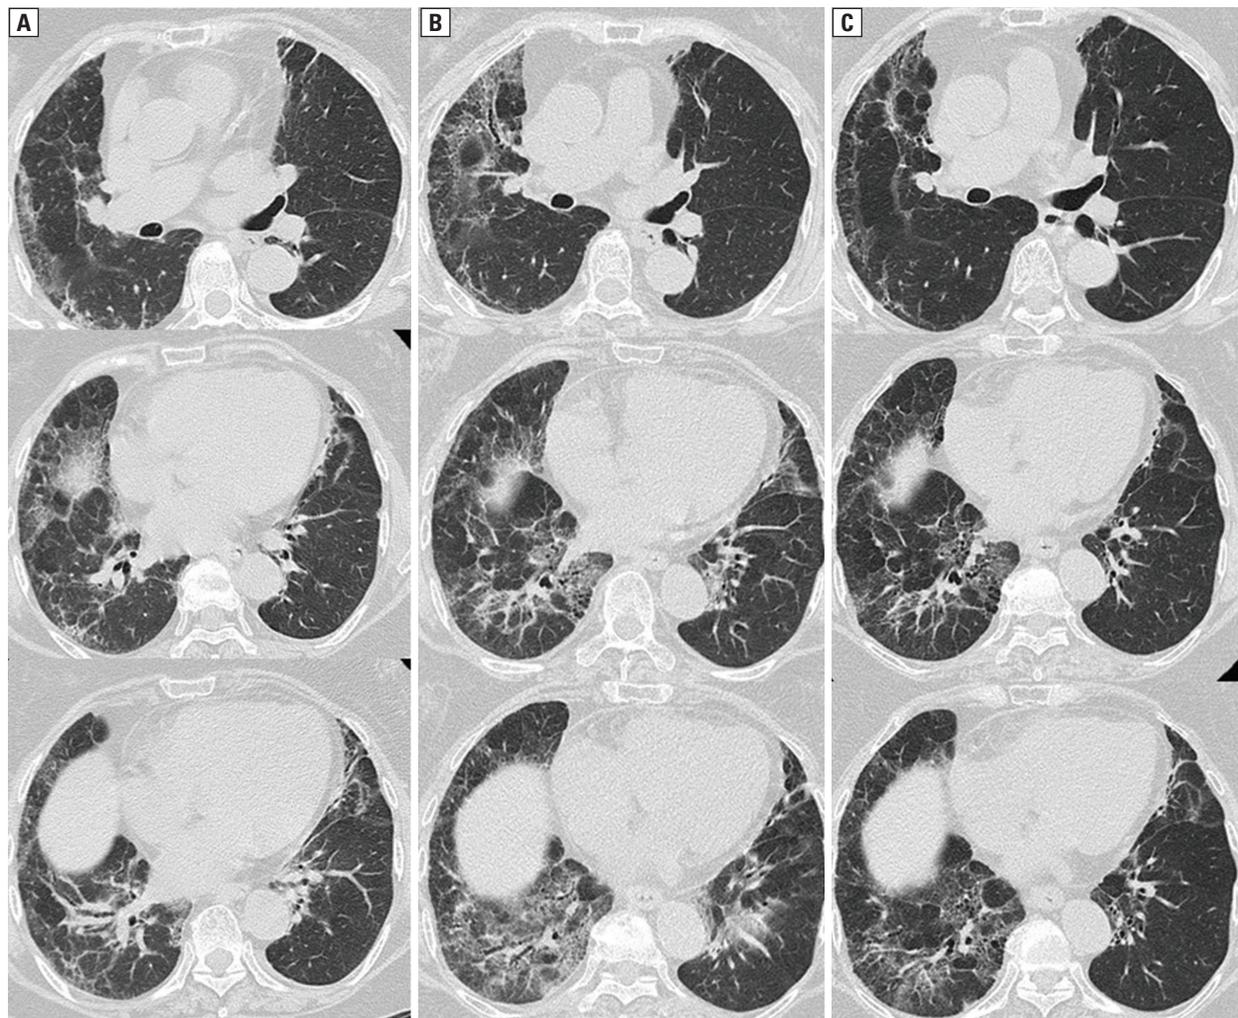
Chest computed tomography (CT) scan 10 months (A) and 26 months (B) after the initial visit to our hospital showed expansion of subpleural ground-glass opacities with thickening of vascular bundle in bilateral lower lobes of the lung. Chest CT scan taken 8 months after the initiation of nintedanib revealed an improvement of diffuse subpleural ground-glass opacities (C)
